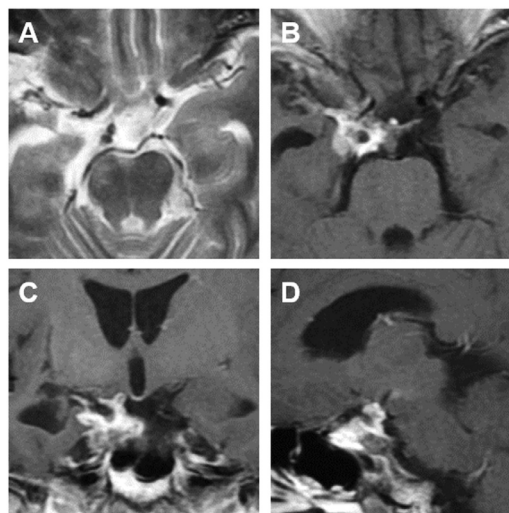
Magnetic resonance imaging performed 5 months after surgery. T2-weighted (A; axial) and gadolinium-enhanced T1-weighted images (B; axial, C; coronal, D; sagittal) show tiny remnants of the lesion in the cavernous sinus
